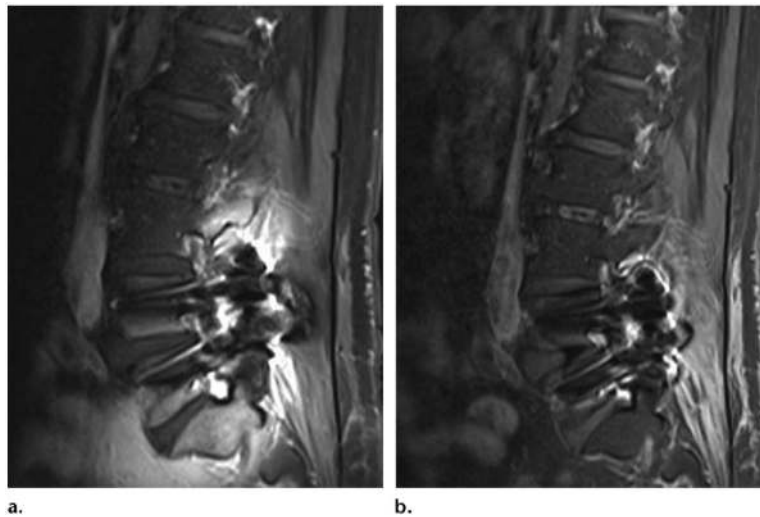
Sagittal T1-weighted MR image with chemical fat saturation (TR, 510 msec; TE, 10 msec) (a) and Dixon (Siemens) MR image (TR, 692 msec; TE, 12 msec) (b) of the lumbar spine obtained in a patient with metal artifacts show that susceptibility artifacts are significantly greater with CHESS than fat-water separation. (Images courtesy of Rory Johnson and Peter Cazares.)
